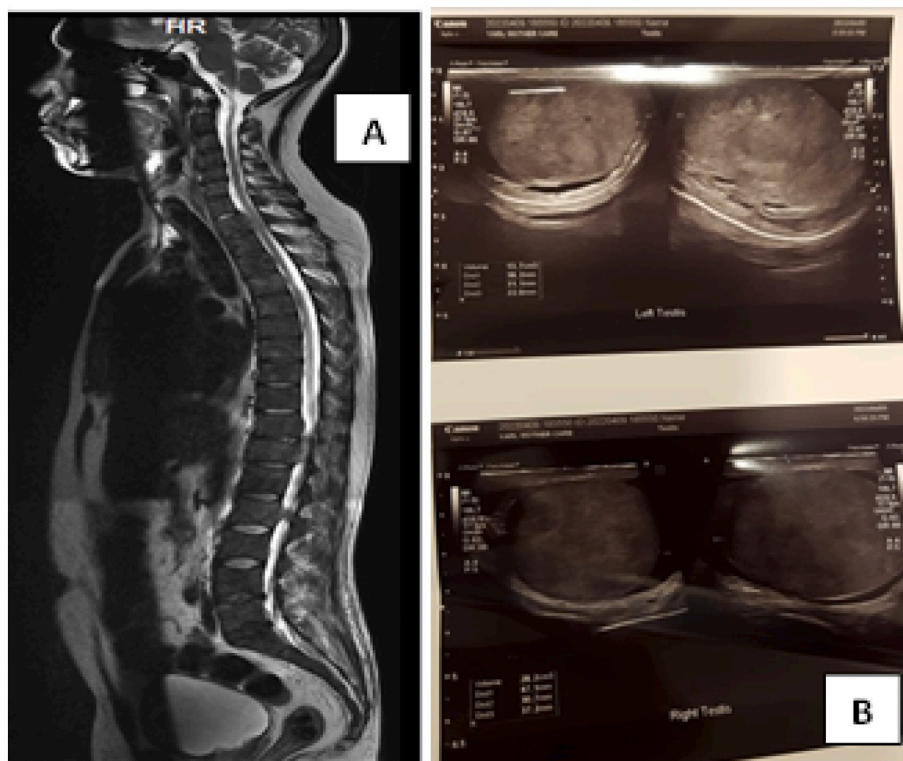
(A): Magnetic resonance image shows prostatic lesion and multilevel thoracolumbar vertebral and skull metastasis (B): Ultrasound scan shows bilateral testicular lesions.
